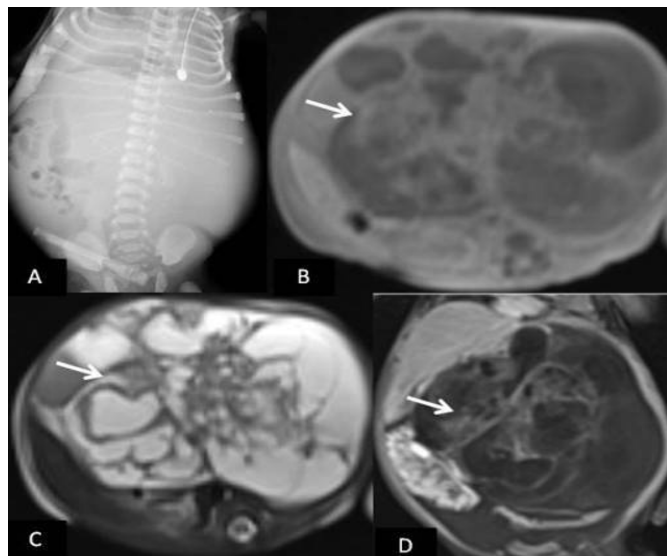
(A) A plain abdominal radiograph shows soft tissue radiolucency on the left side of the abdomen and a shift of the bowel structures to the right. Axial (B) T1W and (C) T2W MR images show a complex mass with a cystic solid structure located predominantly on the left side of the abdominal cavity. (D) A coronal post-contrast T1W MR image shows marked contrast enhancement of the solid components of the lesion
